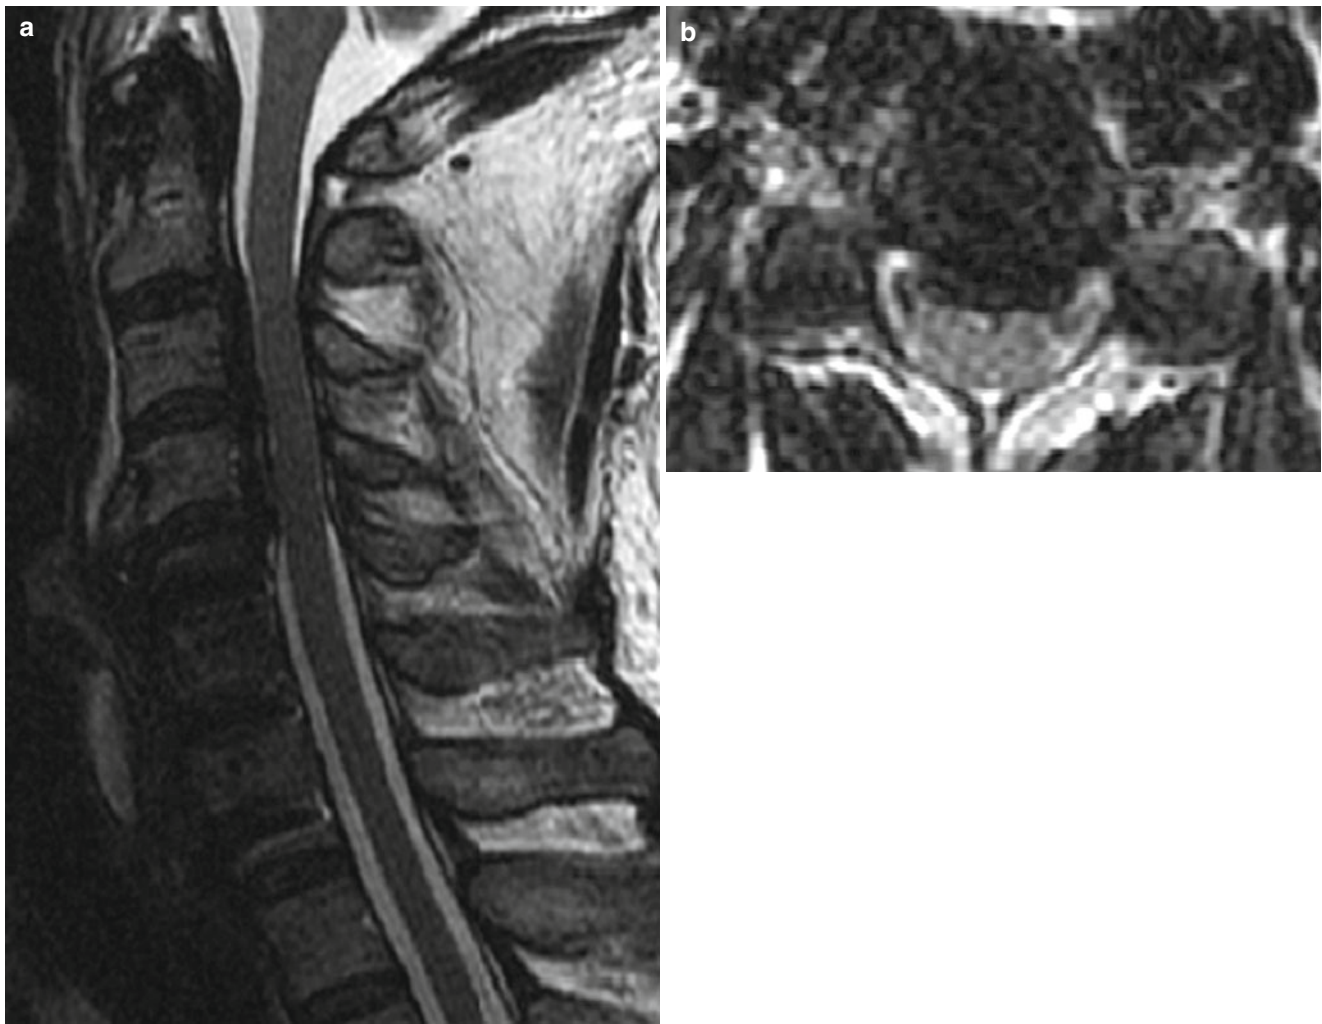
(a, b) Preoperative MRI demonstrated severe stenosis of the spinal cord secondary to ossification of the posterior longitudinal ligament posterior to the body of C3–4, near the rostral aspect of the vertebral body of C5, with consolidation of fusion at C5–6 and C6–7
